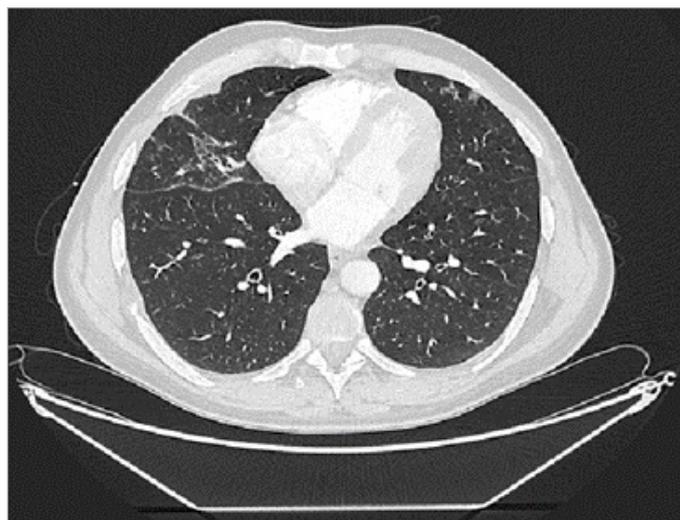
Control CT scan after 4 weeks of antibiotic therapy with complete resolution of necrotizing pneumonia.
